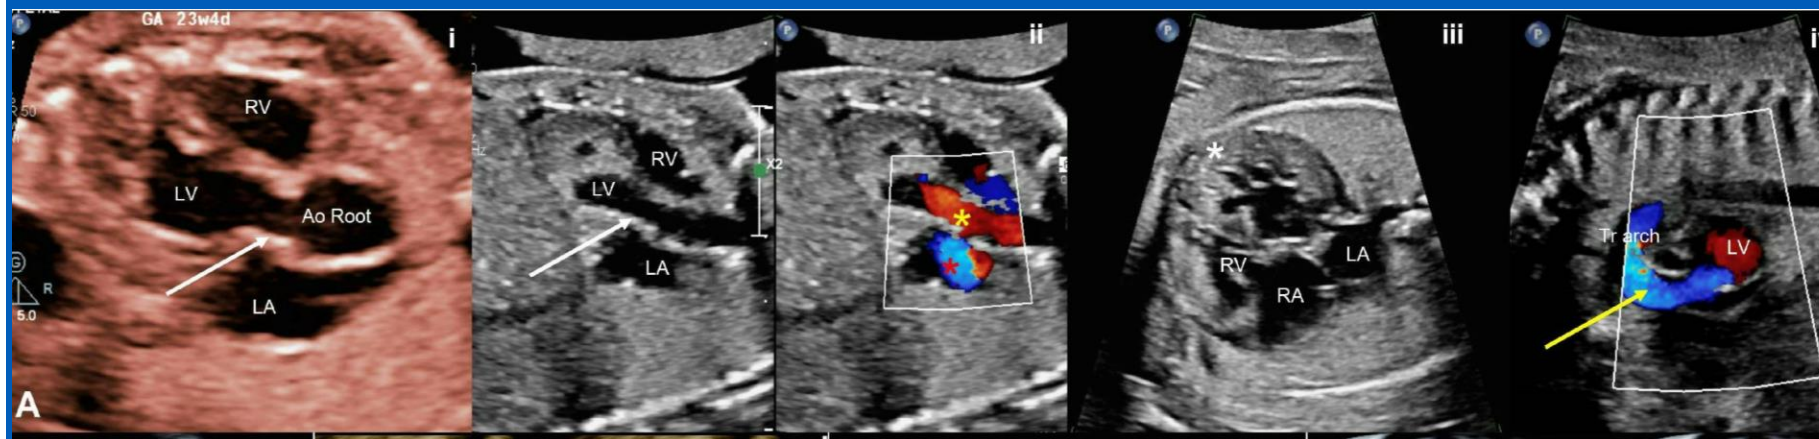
Image A- Fetal echocardiogram: i. Left ventricular outflow view reveals a mildly hypoplastic aortic valve annulus with rudimentary leaflets (white arrow). ii. Color-compare image of the same view showing aortic regurgitation in diastole with concomitant mitral regurgitation (yellow and red asterisks respectively). iii. LV noncompaction with endocardial fibroelastosis (asterisk). iv. Long axis view of the aortic arch with flow reversal across the transverse arch and ascending aorta (yellow arrow).
